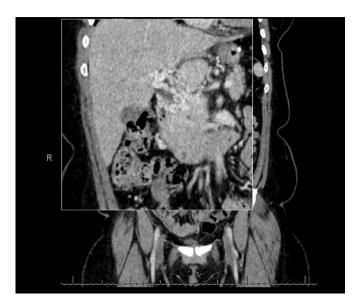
Repeat CT at six-month follow-up shows serpiginous vessels highly suggestive of portal cavernoma.
